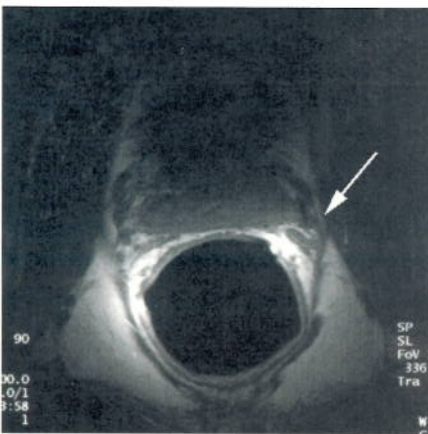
Spin Echo axial T1-weighted (TR 700, TE 17) endorectal coil image of prostate. The neurovascular bundle is clearly seen in the high signal periprostatic fat.
